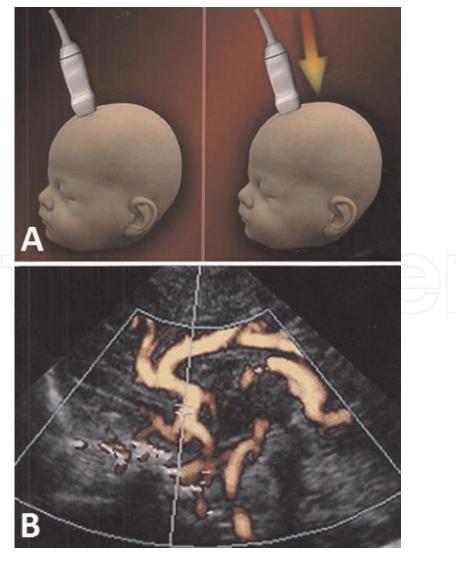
The compression test on the anterior fontanelle. (A) Compression by the sonographic probe, (B) the Doppler curve of the anterior cerebral artery [268].
